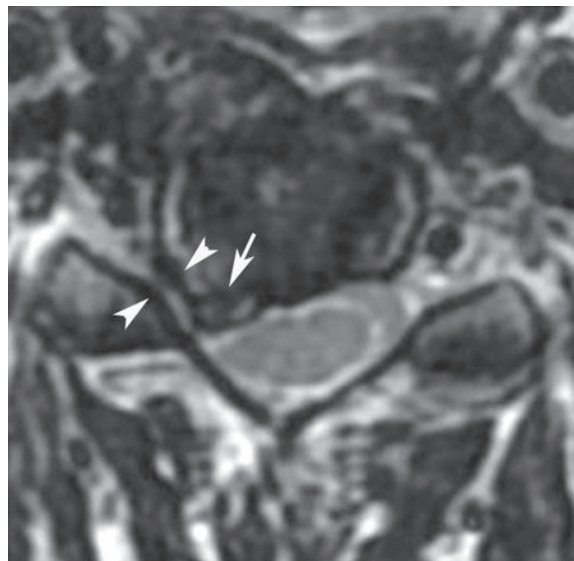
An axial T2-weighted image at the C5-C6 level shows a right posterolateral disc protrusion with associated uncovertebral joint hypertrophy (*arrow*), which produces mild deformity of the right side of the spinal cord and severe foraminal stenosis (between *arrowheads*). Note the normal size of the neural foramen on the left side.[†]
